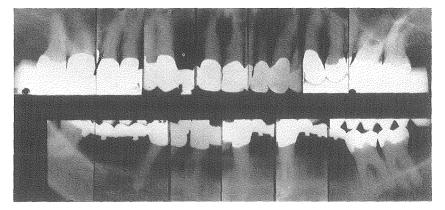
(*Above and Below*). Clinical and roentgenographic appearance of the same case (Fig. 444) 15 years after treatment.
